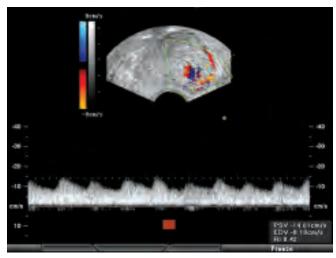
Pulsed Doppler flow velocity wave in the complete mole showed 83 beats/min flow which coincided with the real-time color Doppler observation. RI was as low as 0.42 and systolic flow velocity was as slow as 14 cm/sec *Courtesy:* G Varga
